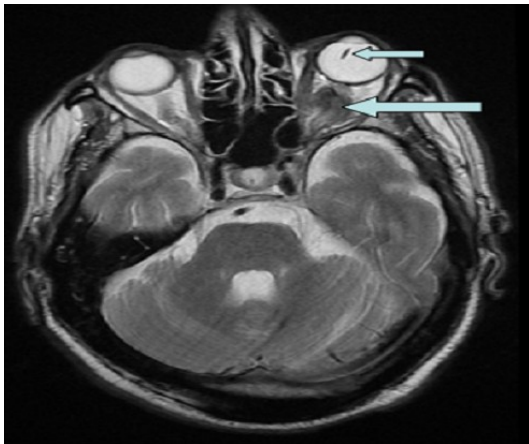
Brain magnetic resonance imaging (MRI) showing metastasis of the optic nerve associated with a lens dislocation
